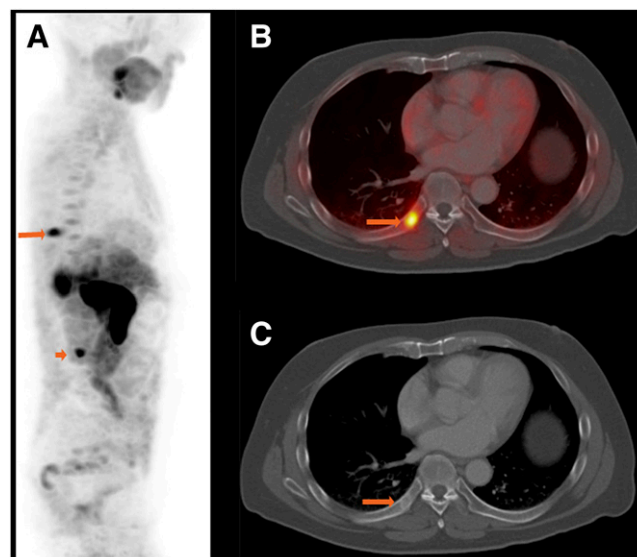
A 67-y-old man with history of prostate cancer who had undergone resection and had rising PSA level. ^{11}C -acetate-avid right eighth rib metastasis is seen on maximum-intensity projection (A, long arrow) and selected axial fused (B, arrow) and CT (C, arrow) images, with sclerotic changes seen on CT. Additional L4 vertebral metastasis is seen on maximum-intensity-projection image (A, short arrow). (Courtesy of Martin Allen-Auerbach and Johannes Czernin, University of California, Los Angeles.)
